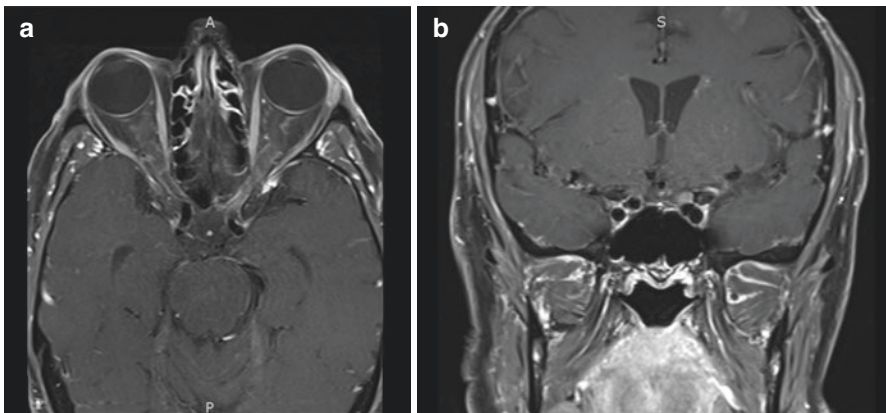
T1-weighted post-contrast (a) axial and (b) coronal MRI images demonstrate bilateral optic nerve sheath enhancement and left optic nerve enhancement, consistent with leukemic infiltration. (© AD Henderson 2021. All Rights Reserved)
